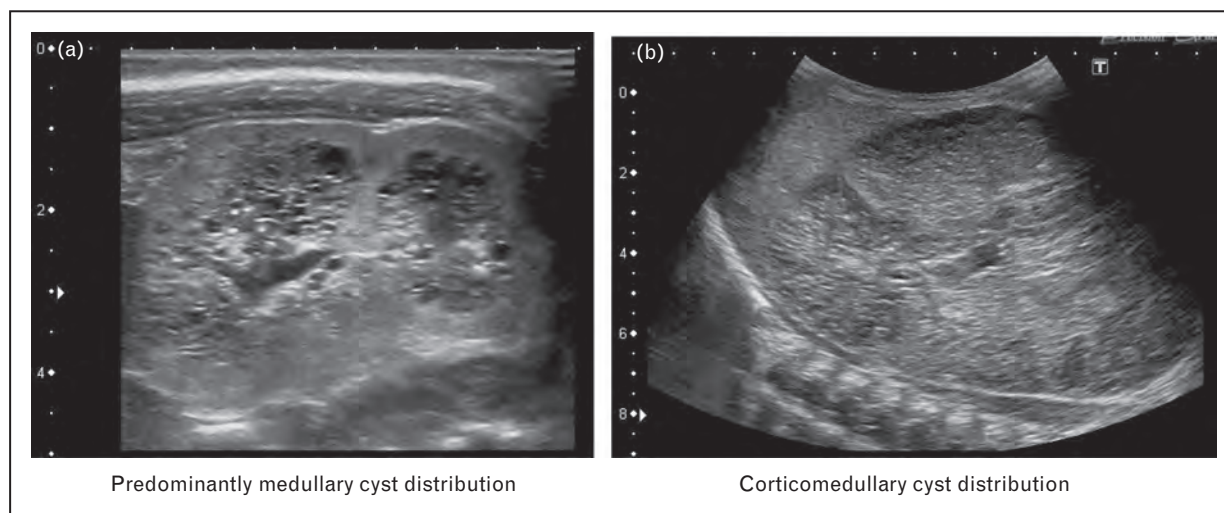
Ultrasound pictures of ARPKD kidneys with various cyst distribution, predominantly in the medulla (a) and diffuse corticomedullary distribution (b). ARPKD, autosomal recessive polycystic kidney disease. Reproduced with permission [8].
